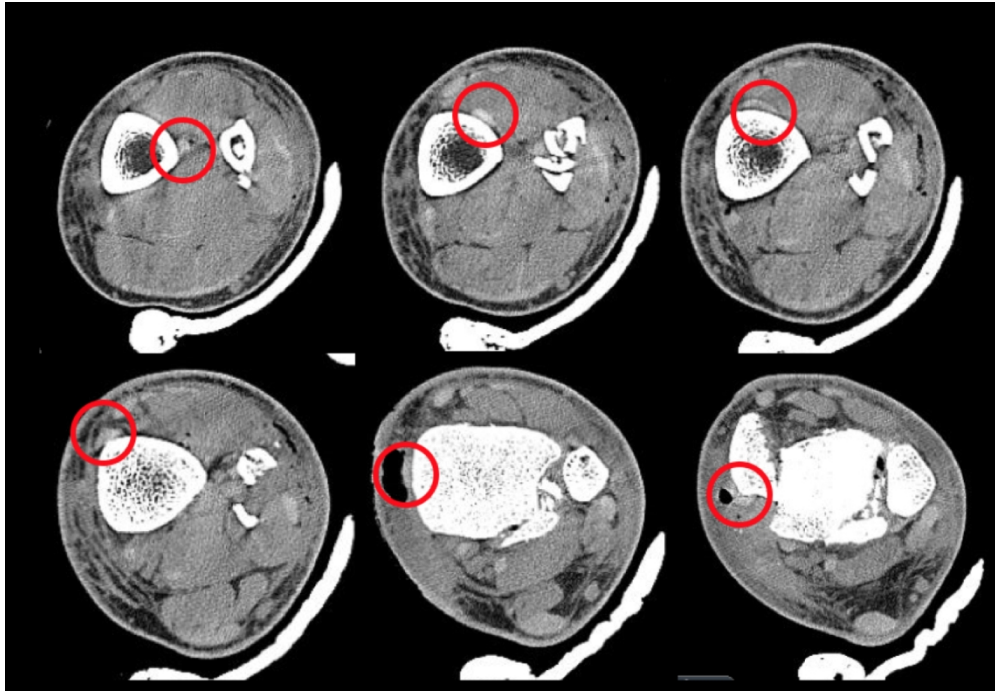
Axial CT sections (proximal to distal in direction of top-left to bottom-right) demonstrating PTT passing through interosseous space across the anterior surface of the tibia, displacing the medial malleolar fragment anteriorly.
